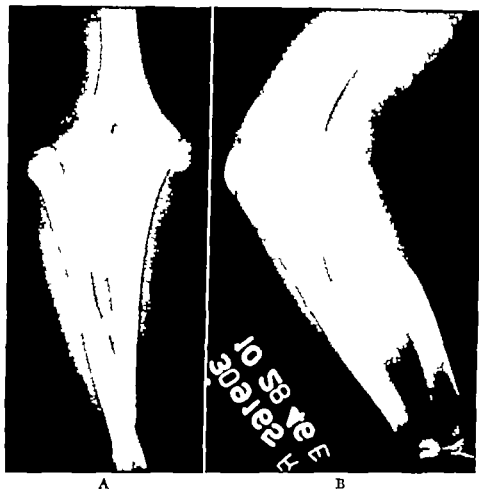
Congenital dislocation at elbow joint which had been present since birth in twelve year old boy with dyachondroplasia. (A) Antero-posterior and (B) lateral roentgenograms.
